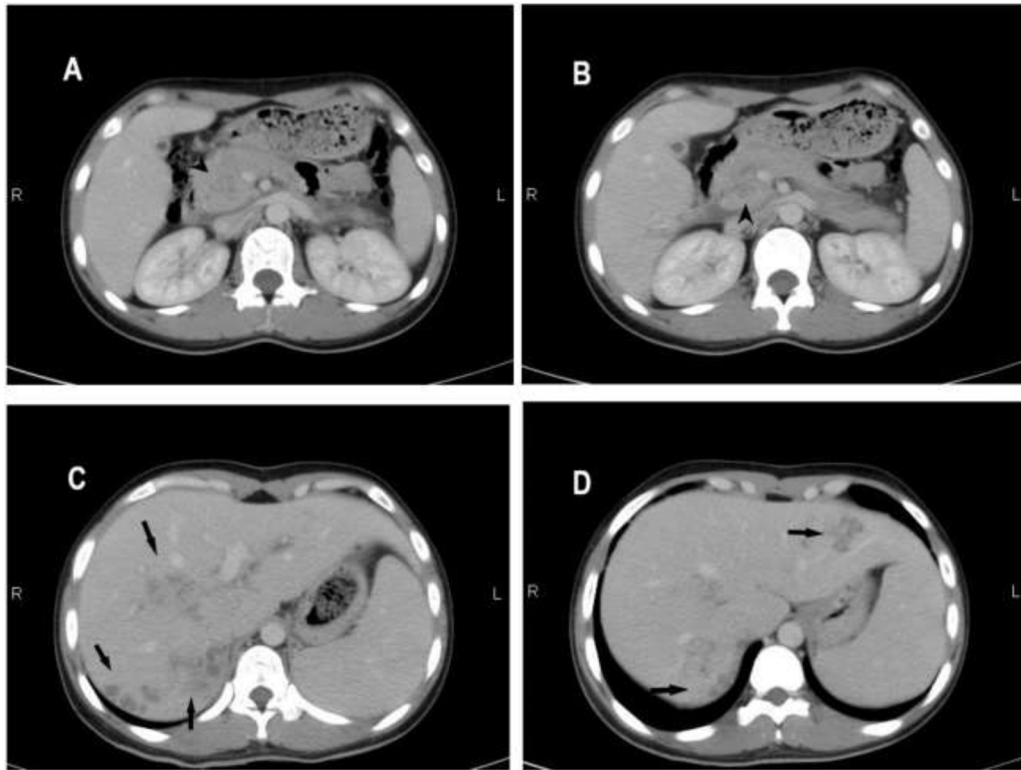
(A–D) The portal venous phase of a CT scan shows multiple, round, clustered, hypodense lesions in the subcapsular liver (arrow) and the head of the pancreas (arrowhead).
